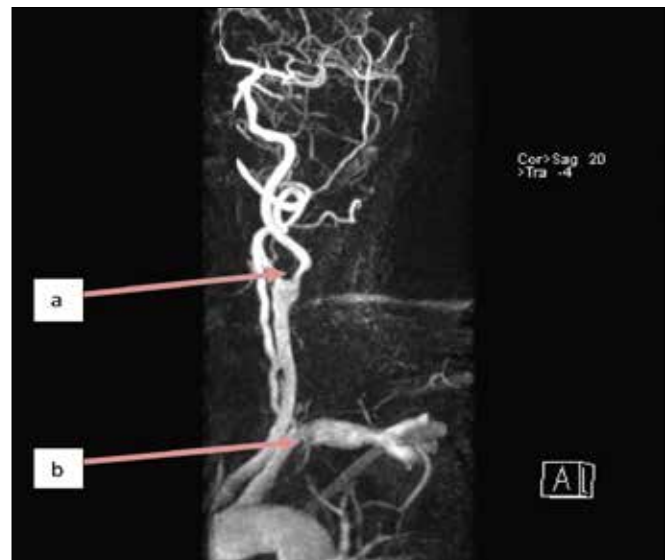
CT Angiogram- Significant disease in the left carotid bifurcation and proximal internal carotid with near complete occlusion of a short segment of the vessel(a). Ulcerated plaque in the proximal left subclavian (b).
